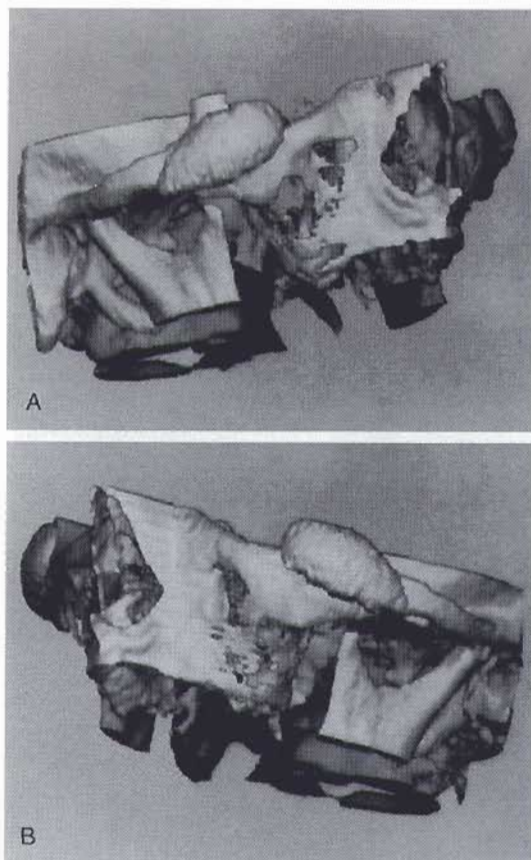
A and B, Manipulating the CT image from the computer workstation produced 3-dimensional radiographic reconstructions of the midface that included the existing implants. The implants are clearly shown to be malpositioned above both right and left infraorbital rims.
